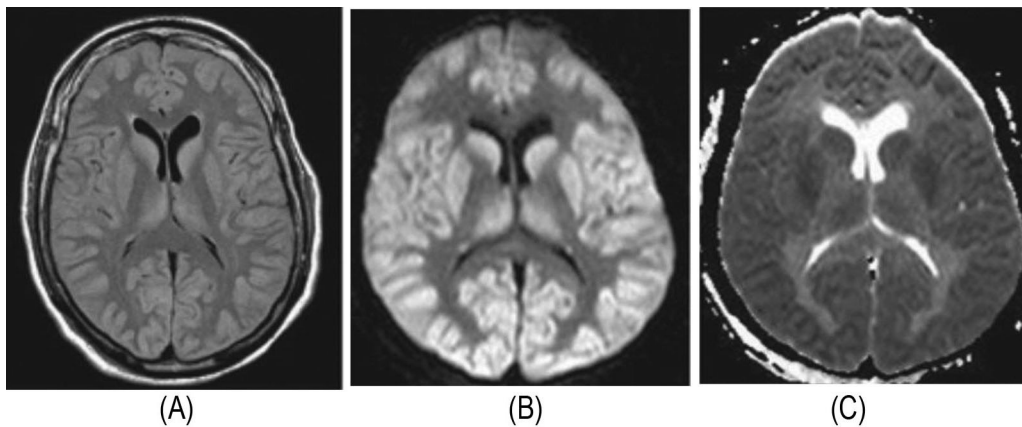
Axial FLAIR image of perinatal hypoxic ischemic encephalopathy showing hyperintensity in bilateral basal ganglia and thalami (A), bright on DWI (B) and dark on ADC (C).
